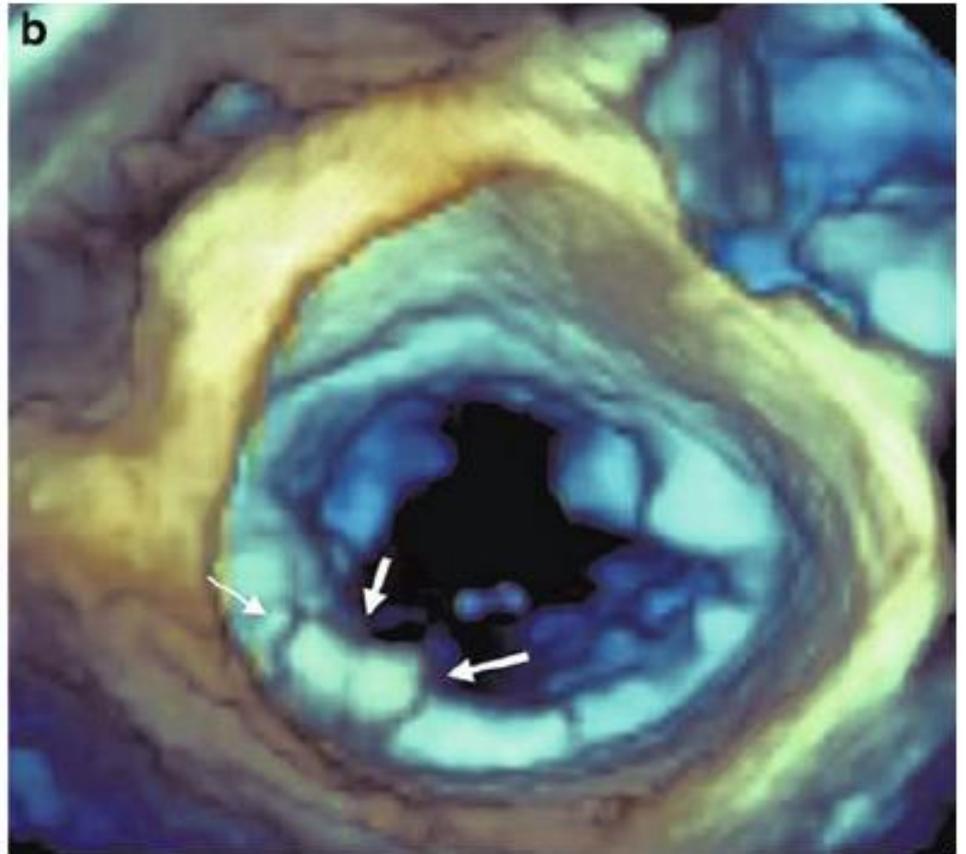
a Three-dimensional echocardiographic images of the mitral valve seen from the atrium in a patient with extensive calcification of the posterior portion of the annulus. It is noted how the calcification, being at the same depth as the leaflets, has the same beige tone. However, it can be distinguished due to its irregular
